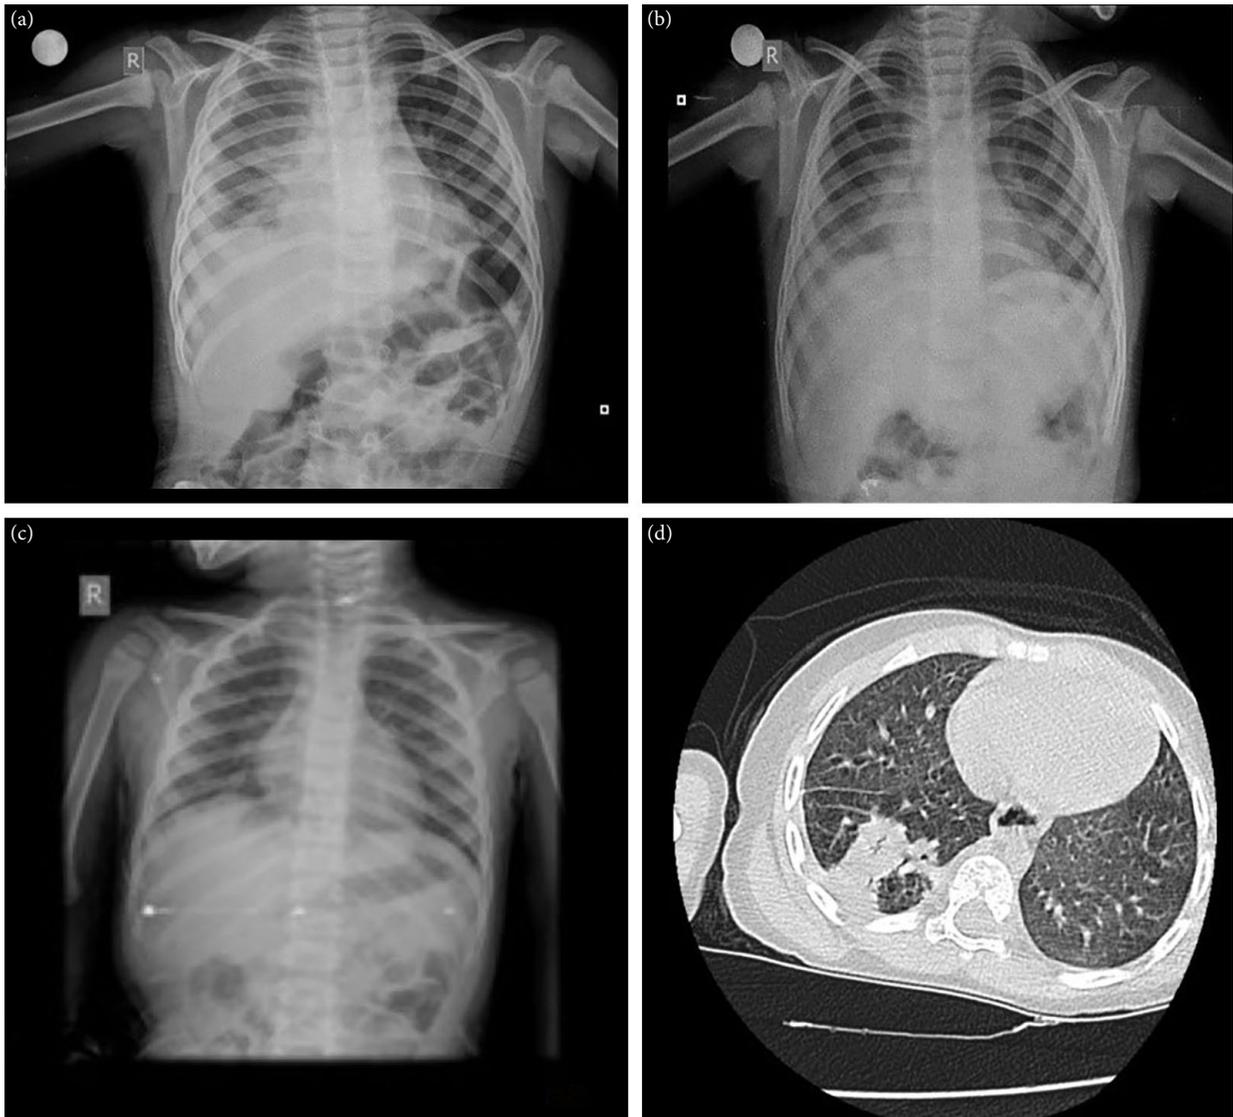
(a) Chest radiograph taken 3 months ago due to cough and fever and infiltration in the right paracardiac and right lower zone. (b) Partial improvement in infiltrations in the right lower zone after 2 weeks of antibiotic treatment. (c) Graph before bronchoscopy when presented with the complaint of hemoptysis and cough. (d) Thorax CT, area of consolidation in the right lower lobe.
